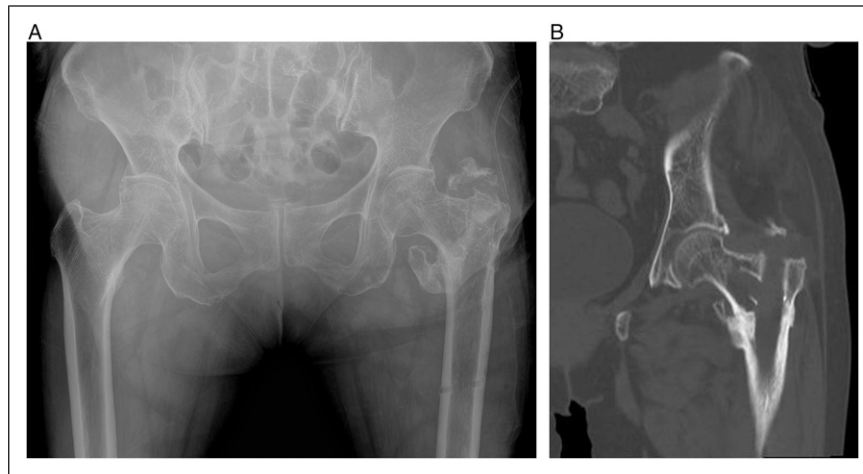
(A) X-ray after removal showed solid fracture site union and partial fragmentation of the greater trochanter tip. (B) CT scan image after removal showed solid union of medial cortex without change of the neck shaft angle.
